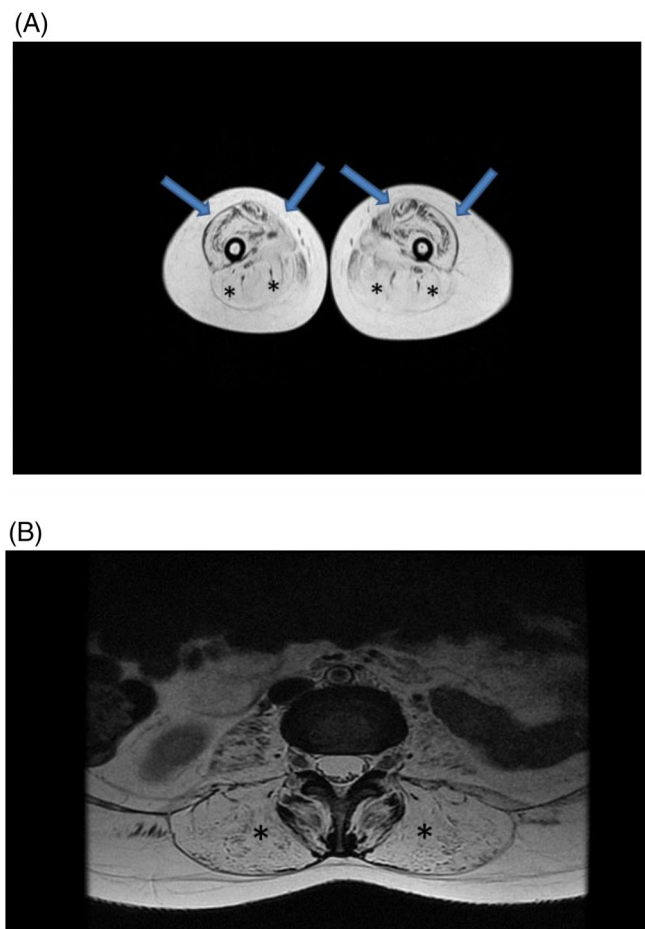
MRI of Family A II-2 patient, homozygous for the p.Lys254del pathogenic variant. (A) Axial T1 weighted MRI of the thighs with severe involvement (Fischer grade 3–4) of all anterior thigh muscles (arrows) with a predominance (Fischer grade 4) in posterior muscles (asterisks). (B) Axial T1 weighted MRI of the lumbar spine of the patient. Severe involvement of paraspinal muscles (Fischer grade 4) (asterisks).
